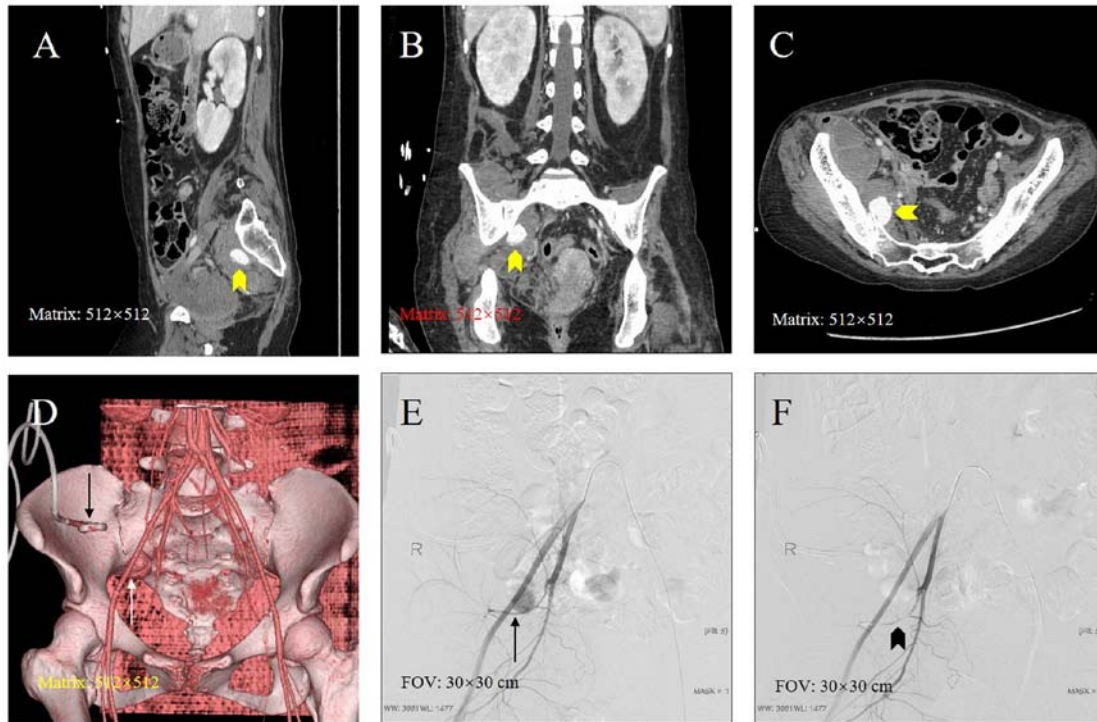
A 25-year-old female patient was diagnosed with a right iliac abscess. (A) Sagittal, (B) coronal and (C) axial CT indicated a pseudoaneurysm (yellow arrowhead) formed after percutaneous drainage of the abscess. (D) CT angiography displayed the size of the pseudoaneurysm and its parent artery, which was compressed and changed to an arc shape (white arrow) and a drainage tube (black arrow). (E) Angiography revealed that the parent artery was pushed inferiorly by the narrowed neck pseudoaneurysm (black arrow). (F) The sandwich technique was used to embolize the sac, inflow and outflow arteries (black arrowhead).
